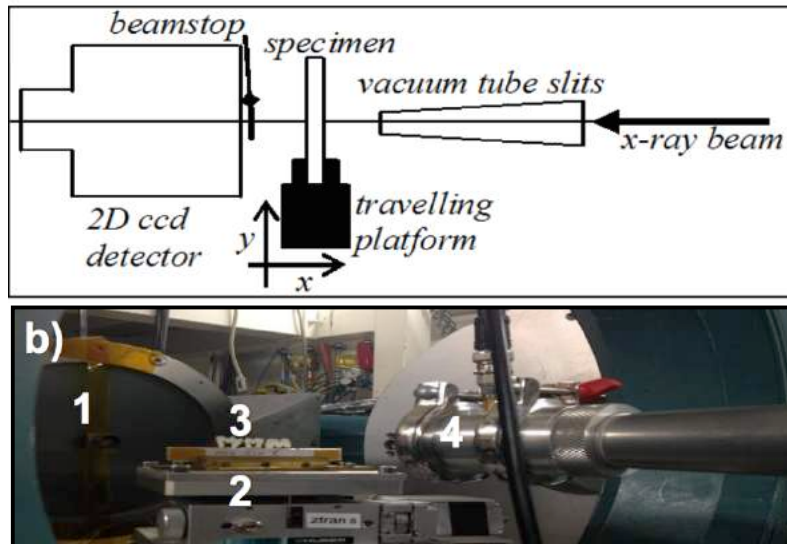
A) Image represents SXR setup (Al-Jawad et al., 2007) B) Image shows the experiment set up at Diamond beamline; 1. 2D x-ray detector; 2. the adjustable platform; 3. Mounted samples on a hard cardboard; 4. X-ray beam tube.
